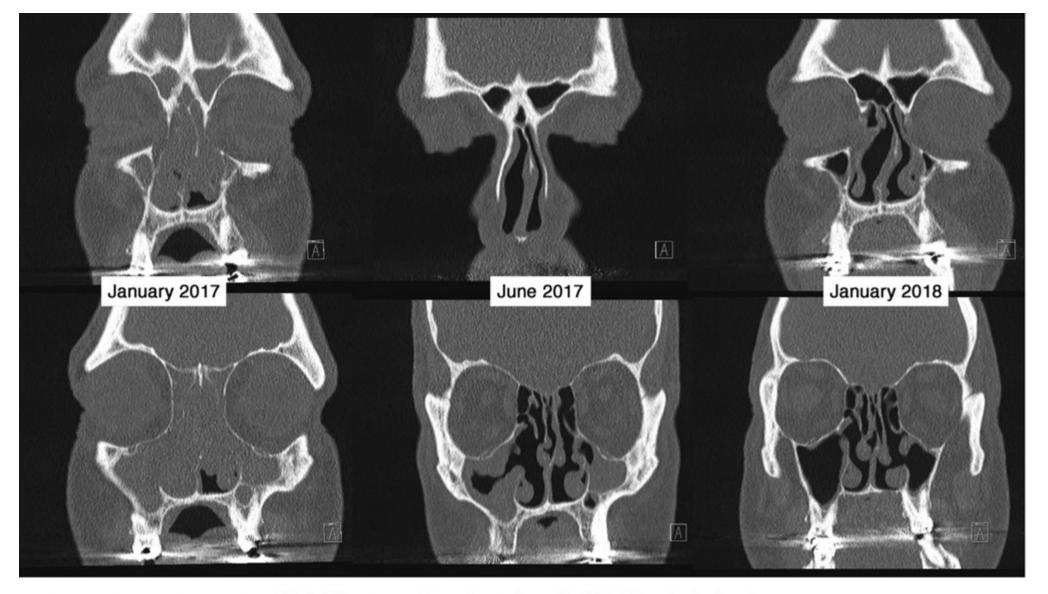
CT scans over 1 year in a patient with CRSwNP under dupilumab.
